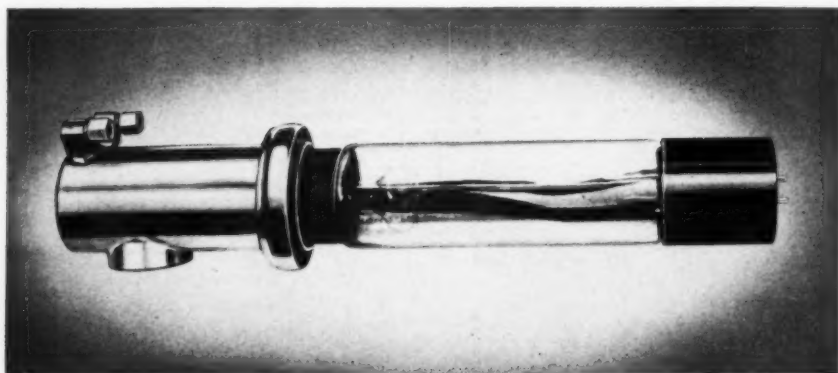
Beryllium-window tube providing 40-degree x-ray beam. (Courtesy Machlett Laboratories, Inc.)
